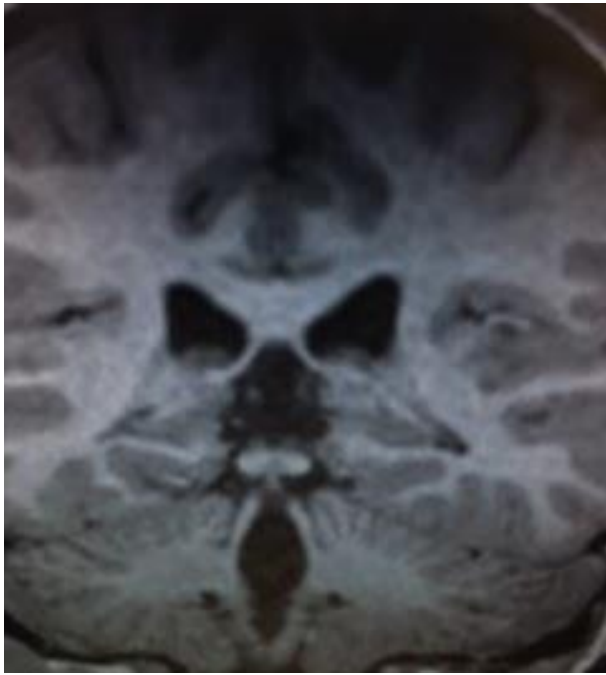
Disappearance of pulvinar without tracing; MRI scan; coronal view
